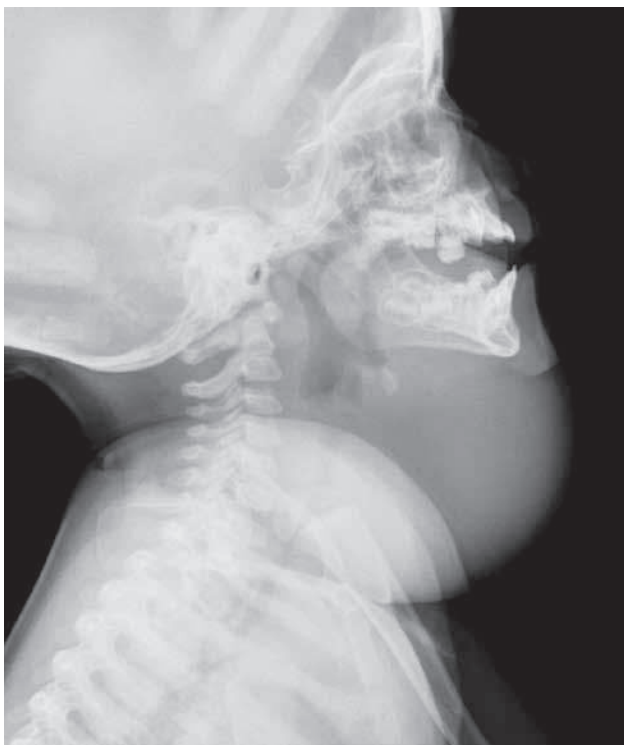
Neck X-ray (lateral view): Soft tissue mass in anterior neck region. Normal imaging of upper respiratory tract.
